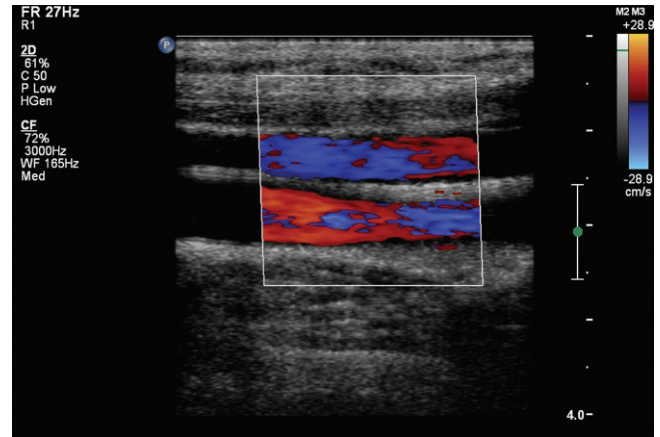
Color box set to straight down, perpendicular to blood flow. At 90 degrees there is no Doppler shift but some off axis flow does create a weak color signal. The direction of flow cannot be assigned since both colors are present in the vessels.
